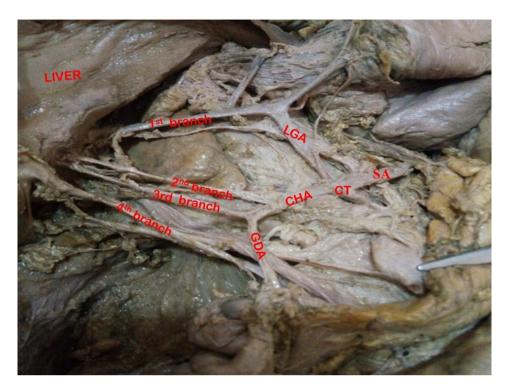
Image of the dissected abdomen showing four different arteries to the liver and other arteries from the celiac trunk (CT)
